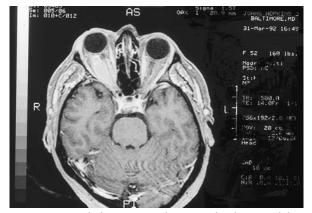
Axial fat-suppressed T1-weighted postgadolinium MR scan of the orbit shows a left enhancing optic nerve sheath meningioma.
